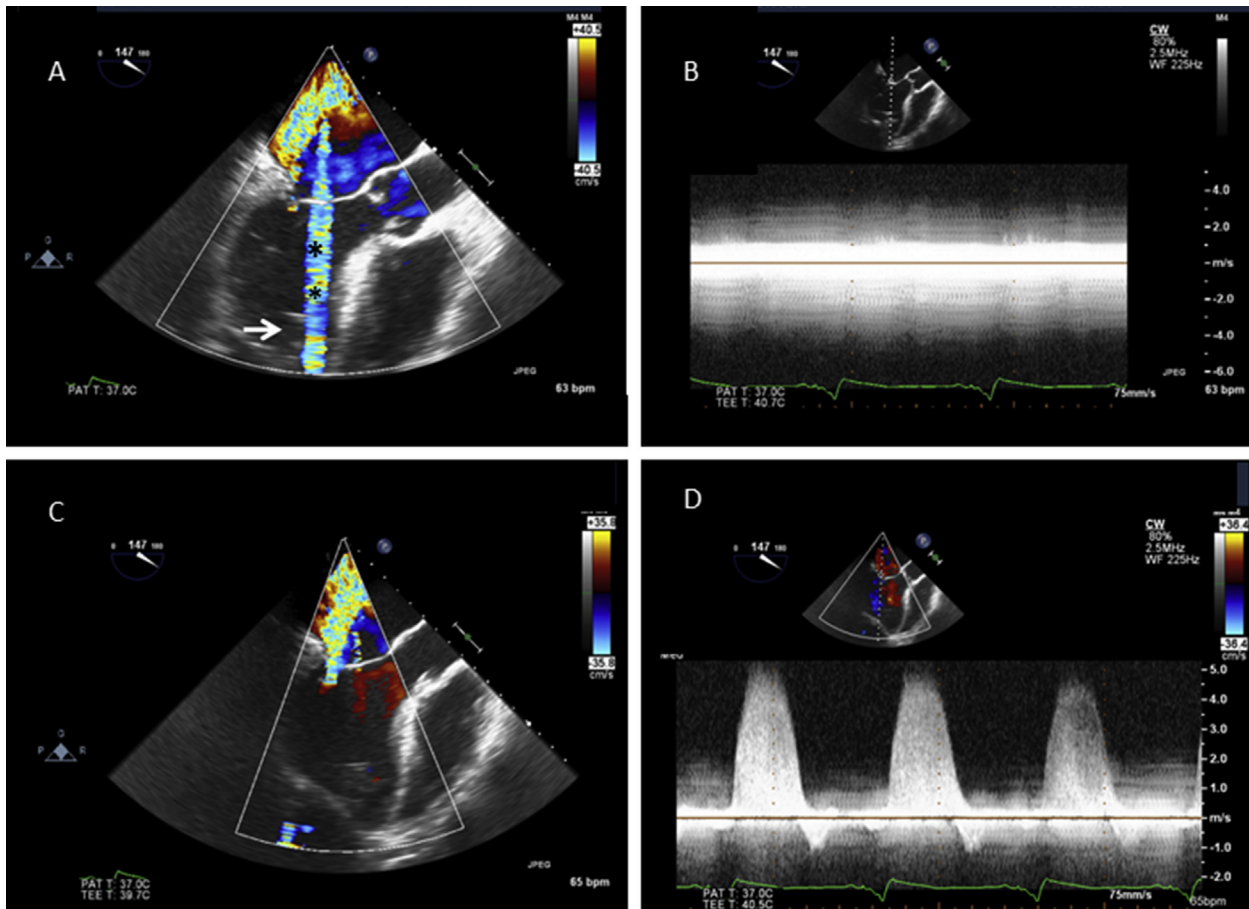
An HVAD inflow-cannula Doppler exam is typically not possible due to the characteristic color artifacts (A) (*) and spectral Doppler artifacts (B). See also [Video 12](#). When the inflow cannula is excluded from the 2D imaging sector (C), the artifacts diminish, and other aspects of the Doppler exam can be performed. (D) Successful continuous-wave Doppler examination of MR in the same patient after slight rotation of the imaging sector away from the inflow cannula. Because the 2D image (view A: *arrow*) suggests that the inflow cannula is directed towards the ventricular septum, normal inflow-cannula flow must be confirmed by other methods, whether TEE or TTE. See also [Video 13](#).
